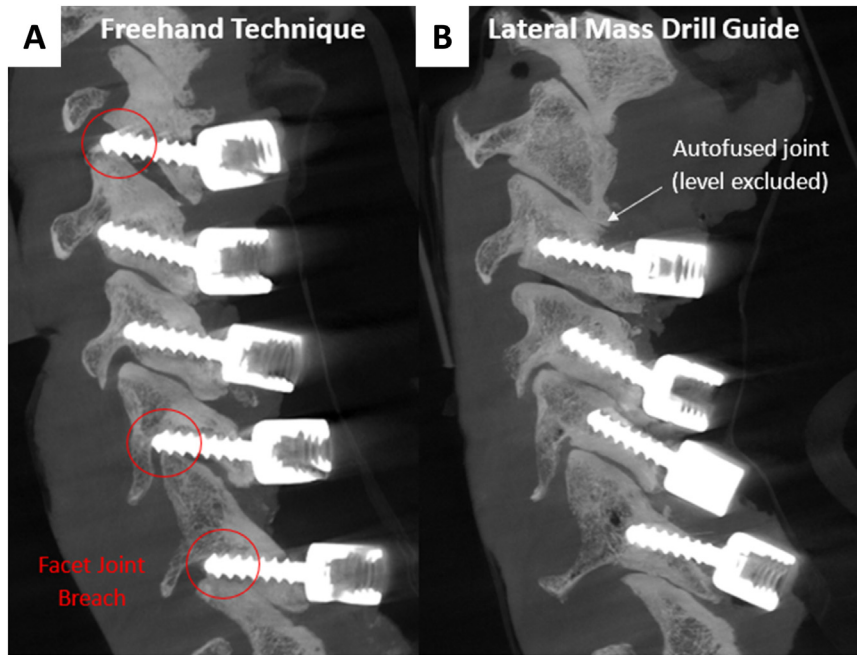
Sample CT image of lateral mass screws inserted bilaterally by the same surgeon using two different techniques, freehand on the left (Left) and LM Guide on the right (Right). On the freehand side, three instances of facet joint breach are visible (red circles).
